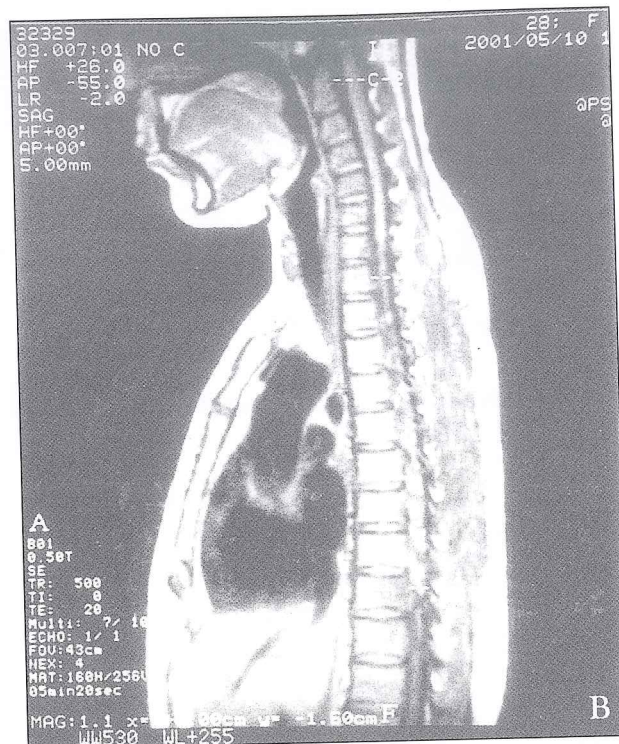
A thoracic MR image of (A) Th7 level showing an extramedullary lesion extending displaying to the spinal canal, (B) Th9 level showing a lesion in the corpus and lateral pedicle.
